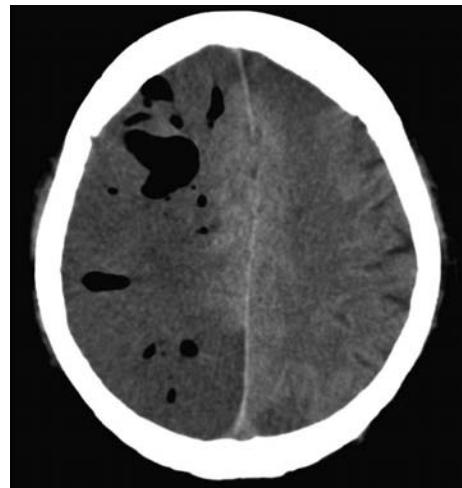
CT scan shows extensive cerebral air embolism with air bubbles in the arteries and pneumocephalus with air that leaked into and became trapped in the perivascular space (Virchow-Robin space) of the right cerebral hemisphere.
